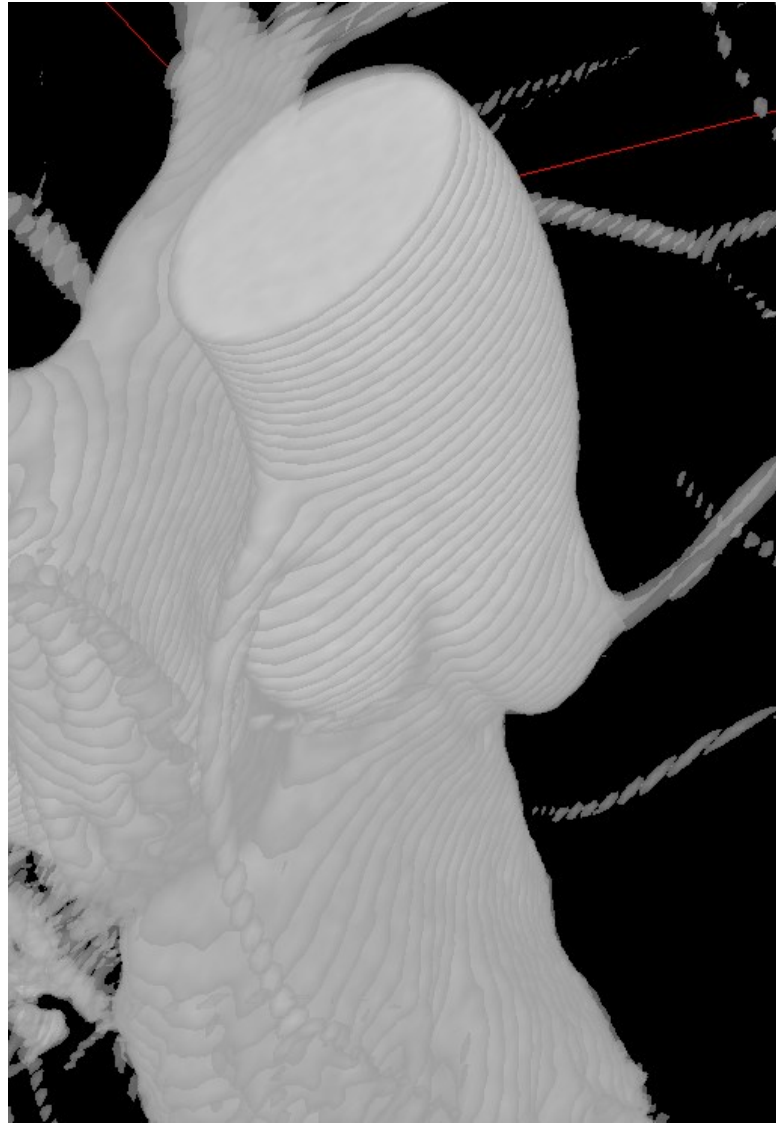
An aortic root constructed from patient data. The striations represent the individual images of the CT scan.
